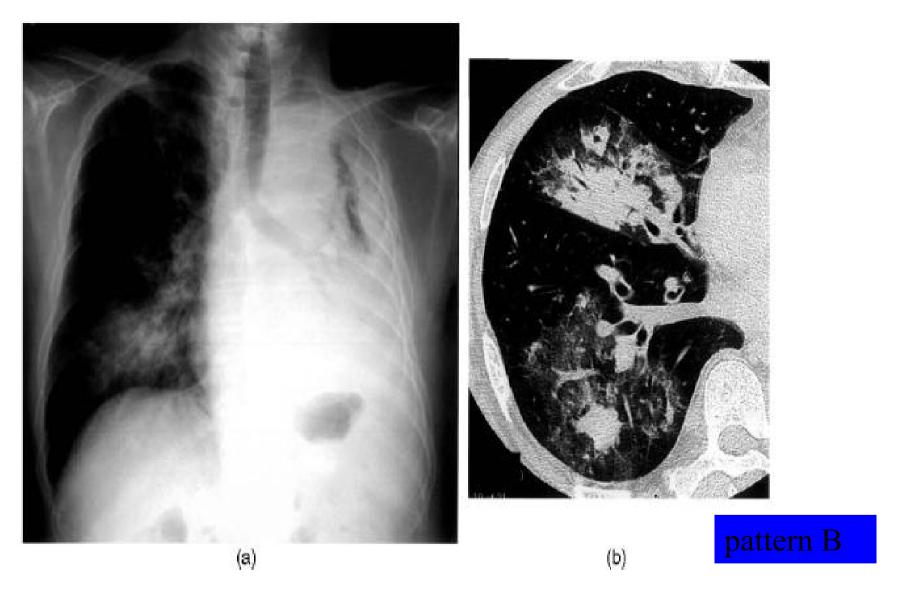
A 70-year-old male with stage IIIB adenocarcinoma who had been treated with platinum-based chemotherapy was started on gefitinib, and developed a severe cough and mild dyspnea on day 30 of gefitinib therapy. The chest radiography shows areas of consolidation on the upper and lower field of the right lung (a), and multifocal areas of airspace consolidation are seen on the thin-section CT scan (b).
